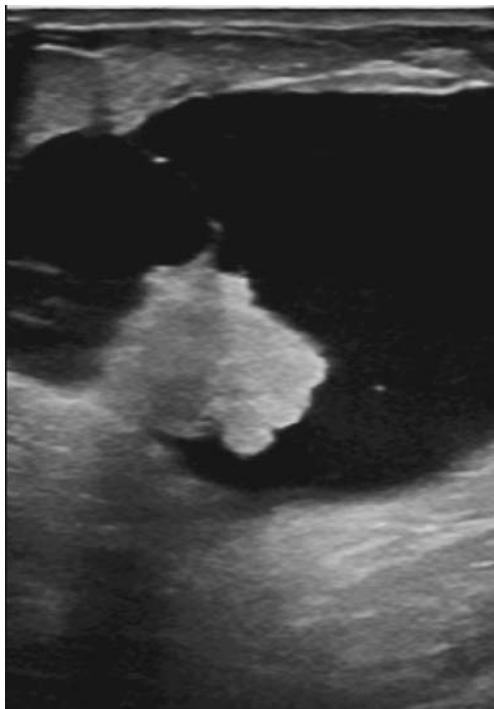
Left breast ultrasound from case 4 demonstrating a 10-cm cyst containing a 1.6-cm echogenic nodule
